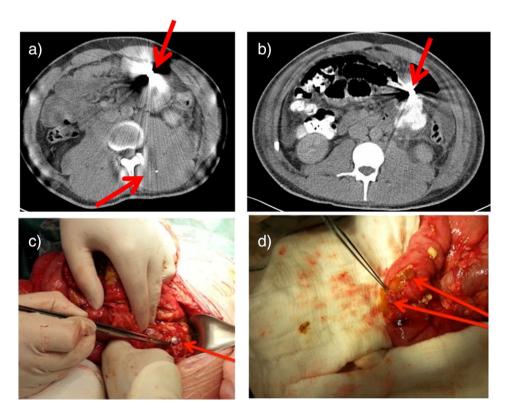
a) Initial CT scan showing retained pellet fragment inferior to transverse colon. No bowel perforation was visualised at this time. There are also retained pellets in the posterior musculature of the back. b) Interval CT scan day 6 post admission showed significant free fluid intra-abdominally, likely originating from small bowel at the level of the foreign body, consistent with a delayed perforation of small bowel. c) Laparotomy demonstrating bullet fragment. d) Laparotomy demonstrating two small bowel perforations.
